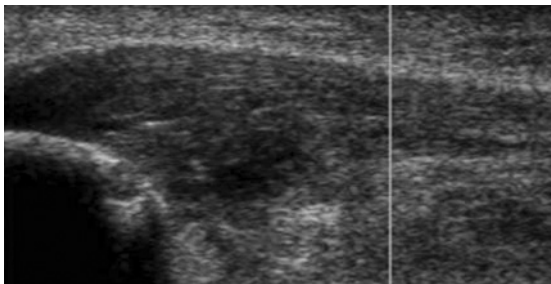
Tendon pathology can be detected as a hypoechoic appearance when the tendon is scanned using gray scale ultrasound
